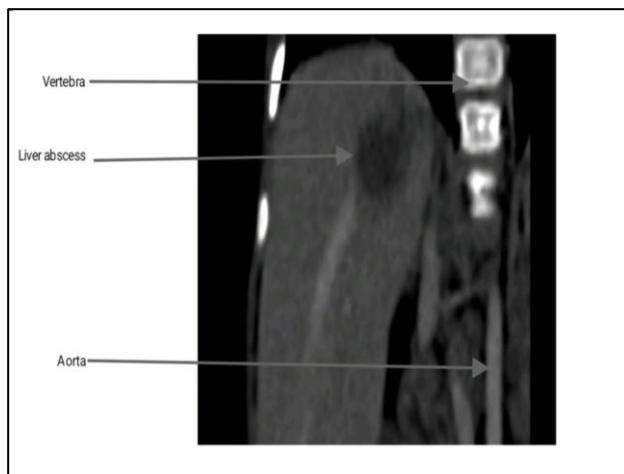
Contrast-enhanced CT (sagittal view) showing hepatic abscess adjacent to the aorta and vertebra
